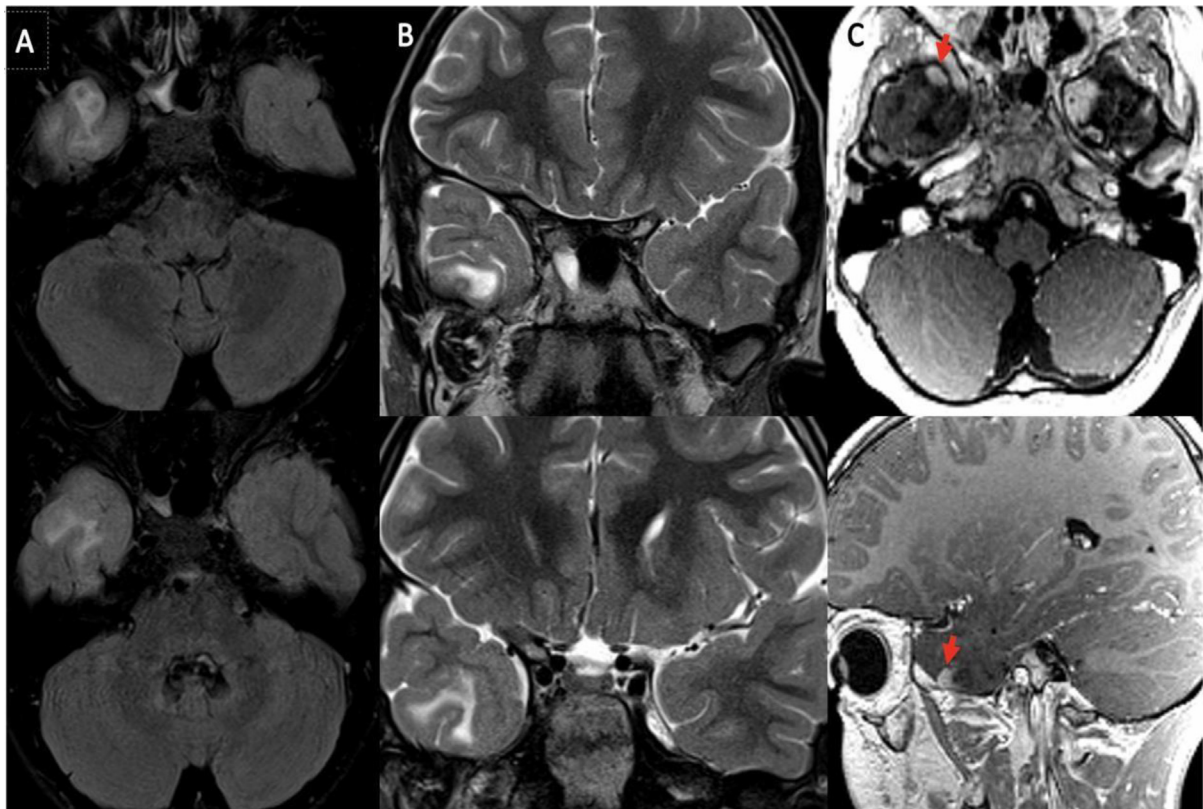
Brain MRI of temporal lobe tumor. Consecutive slices of axial T2W FLAIR.
